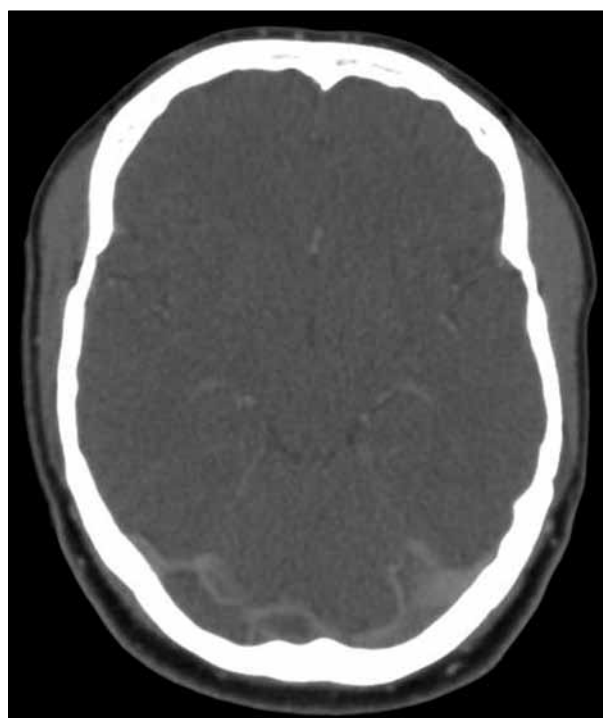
Right transverse sinus filling defect in keeping with cerebral venous sinus thrombosis. No abnormality was noted on a non-contrast computed tomography head scan (case 3).
